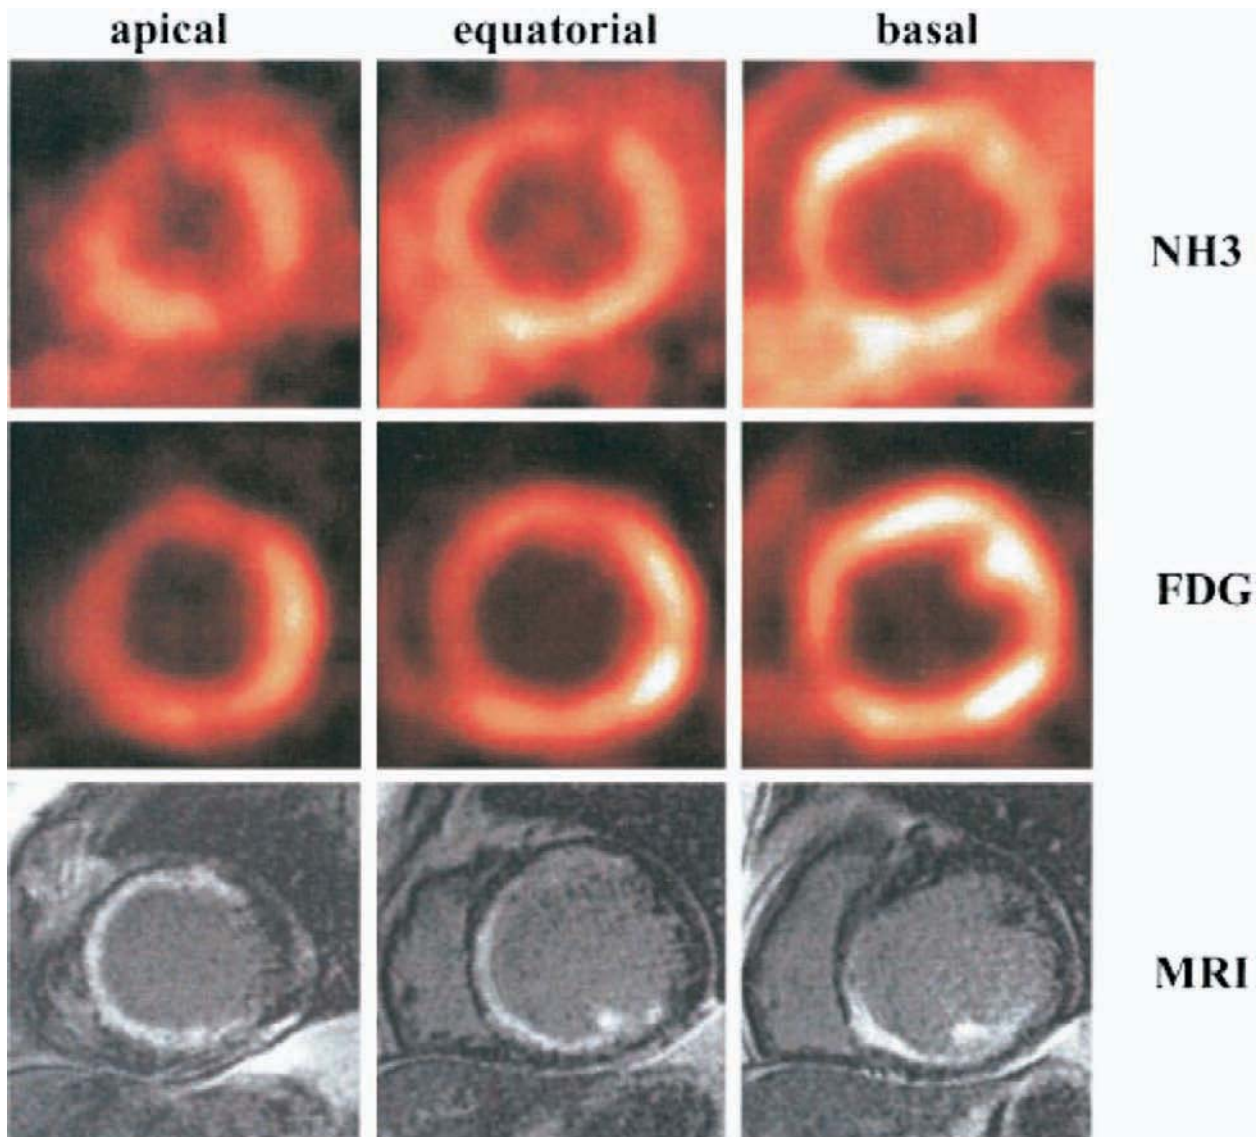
Example of delayed-enhancement MRI and PET viability study including assessment of resting perfusion with ammonia (*NH₃*) and glucose metabolism with FDG in a patient with ischemic heart failure. The delayed enhancement in the areas showing reduced perfusion and FDG uptake should be noted. The high spatial resolution of MRI allows distinction between subendocardial, transmural, and papillary defects. (Reproduced with permission from Klein et al.⁷⁰)
